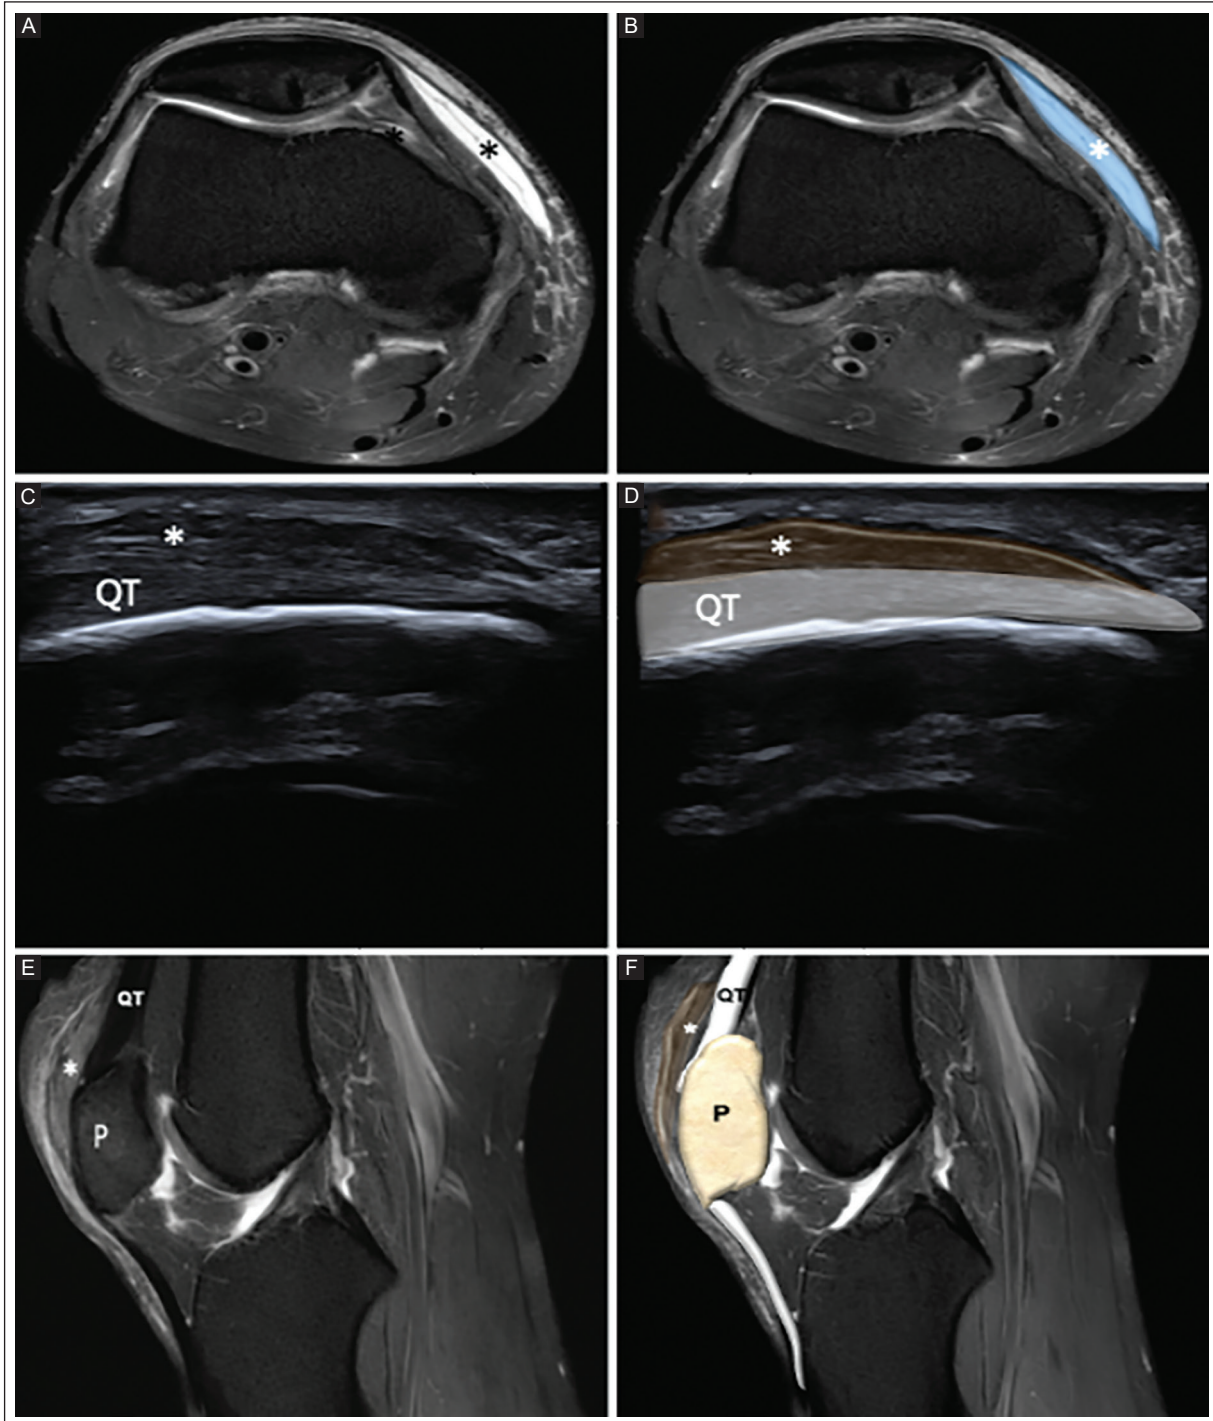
A-B: axial proton density-weighted knee MRI with fat suppression in a 17-year-old man shows post-traumatic hematoma along the medial aspect of the knee, located in soft tissue (asterisks) and highlighted in blue. No prepatellar bursa involvement is observed. C-D: longitudinal US view of the anterior knee shows post-traumatic fibrotic thickening of the prepatellar tendon, characterized by focal tendon enlargement with a predominantly hypoechoic echotexture and changes in the normal fibrillar pattern (asterisks). The affected tendon segment is highlighted in dark brown. E-F: sagittal proton density-weighted knee MRI views with fat suppression show post-traumatic fibrotic thickening of the prepatellar tendon (asterisks), characterized by tendon enlargement with predominantly low signal intensity and focal areas of intermediate signal, without fiber discontinuity or hyperintense fluid signal suggesting tendon rupture. The affected tendon is highlighted in dark brown.
